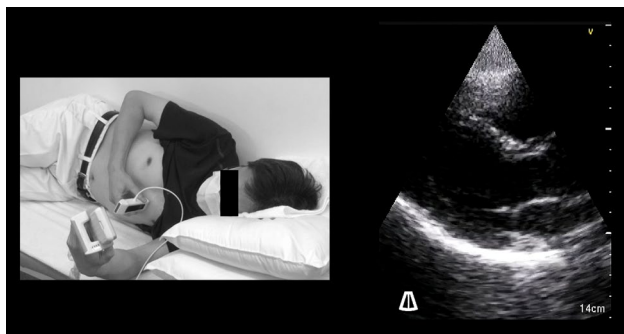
Demonstration of self-performed focused cardiac ultrasound using a handheld device during a video lecture. An experienced doctor visualized the parasternal long-axis view
